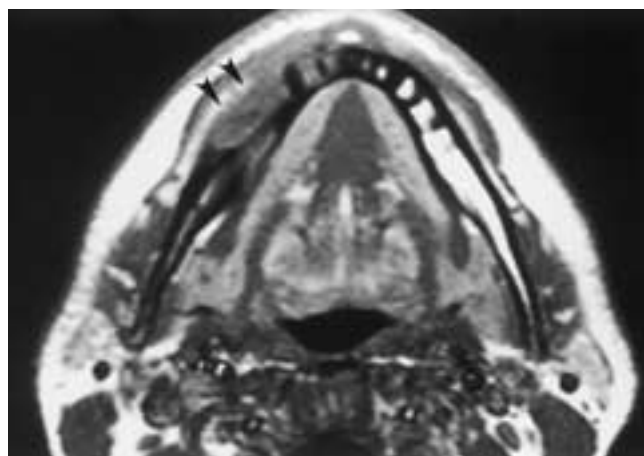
Eosinophilic granuloma. Axial T1-weighted MR image demonstrates a destructive lesion involving much of the buccal cortex of the mandible on the right and extending into the soft tissues anteriorly (arrowheads).
